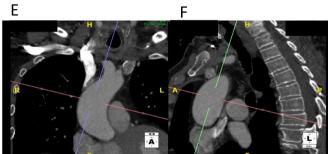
CT images with reconstruction of preoperative assessment for patient undergoing ART AVR (from top left to right): (A) Three-dimensional (3D) reconstruction showing location of ascending aorta to the right of the sternum. (B) 3D reconstruction of the great vessels and myocardium within the thorax, having removed the sternum and ribs anteriorly. (C) Axial image at the level of the mid-ascending aorta providing cross-sectional dimensions: area, diameter and perimeter. (D) Reconstructed surface anatomy of the patients thorax highlighting the third and fourth rib spaces and location of the ascending aorta. (E) Coronal CT image of the ascending aorta highlighting its distance from the planned ART incision. ART, anterior right thoracotomy; AVR, aortic valve replacement.
